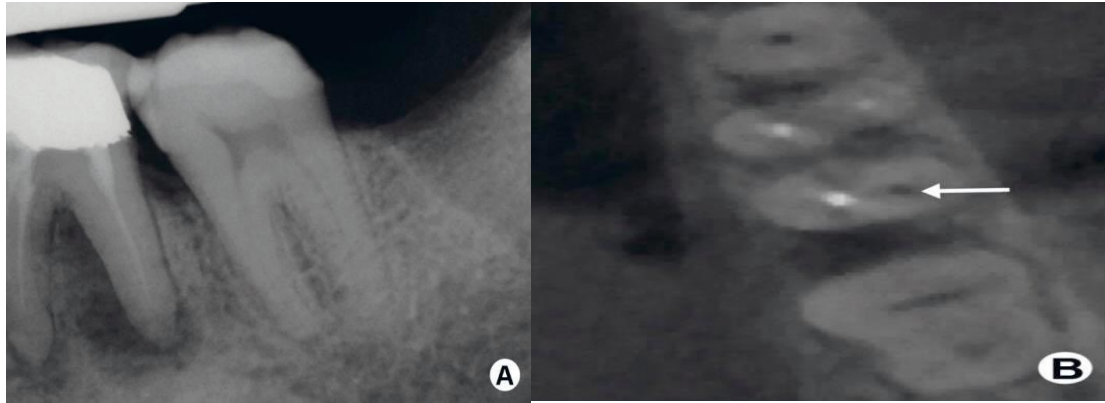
(a) Periapical radiograph of a mandibular left first molar tooth with a 10o horizontal shift in the angle of the X-ray tube head. There is no evidence of a second distal canal on this image despite the oblique view taken. (b) Axial CBCT slice through the same tooth clearly demonstrating the presence of an uninstrumented disto-buccal canal (white arrow).
